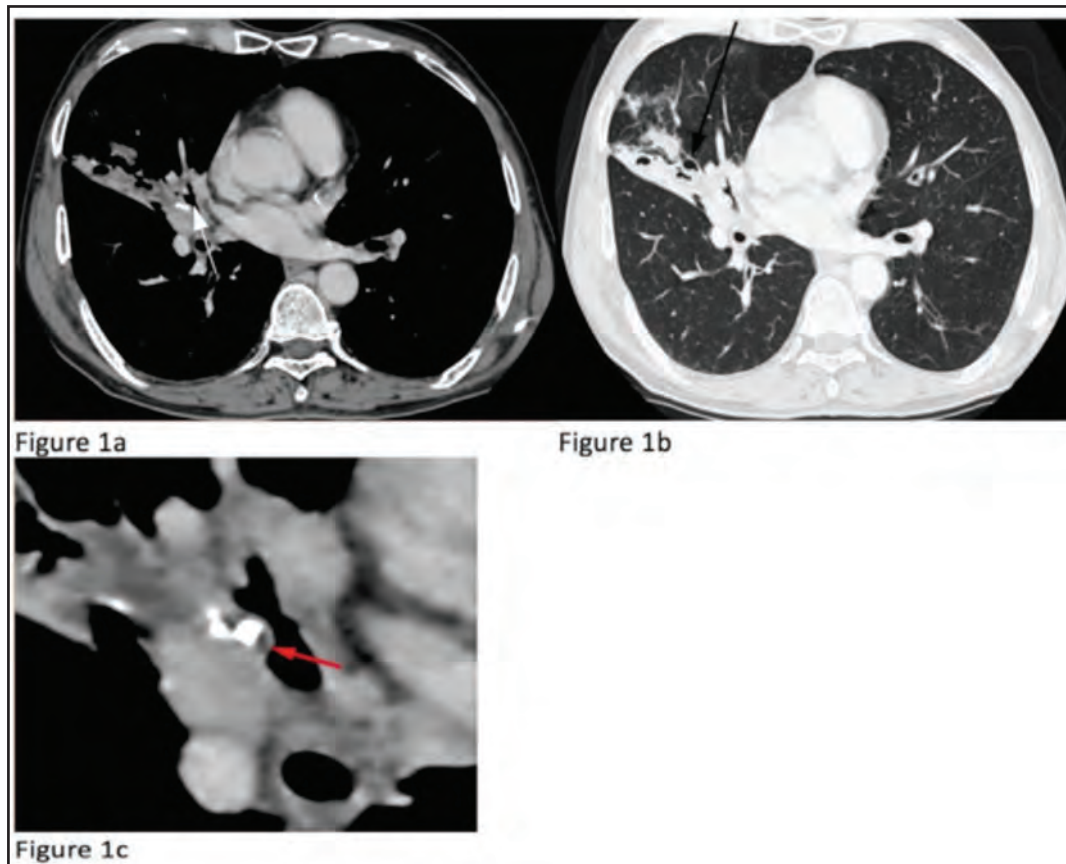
Contrast-enhanced CT Thorax in mediastinal window (Figure 1a) and lung window (Figure 1b) axial views show an oval-shaped hypoattenuating endoluminal lesion with popcorn calcifications (white arrow in Figure 1a) as well as macroscopic fat with an attenuation value of -40HU (red arrow in close-up image in Figure 1c) within the right middle lobe bronchus. It is associated with bronchiectatic airways of the right middle lobe (black arrow in Figure 1b).
